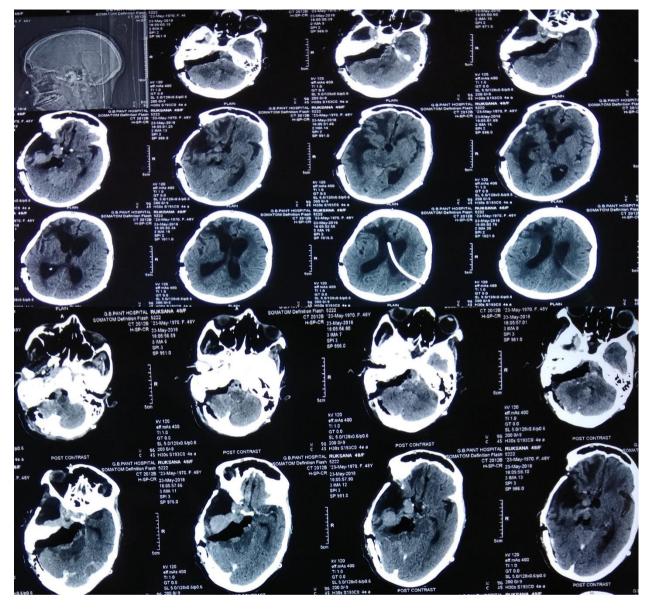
CT brain palin and contrast post-operative images showing total removal of meningioma in C P angle with residual tumor in cavernous sinus with vp shunt in situ.
